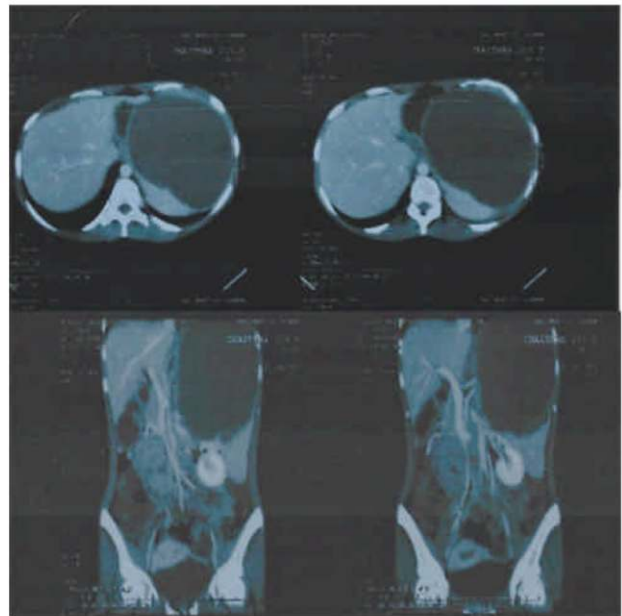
CT scan showing the cyst in the spleen
